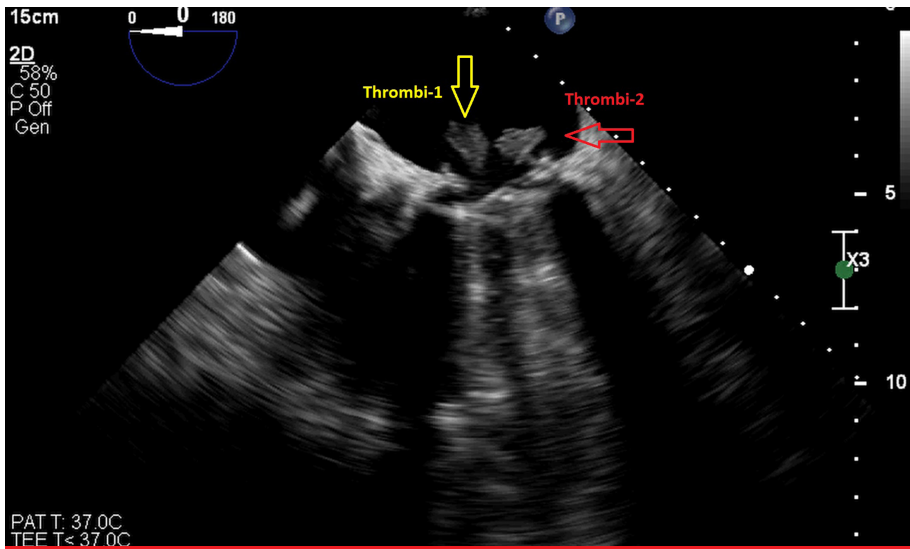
Views of thrombus formations in mechanical mitral valve position by transesophageal echocardiography.
